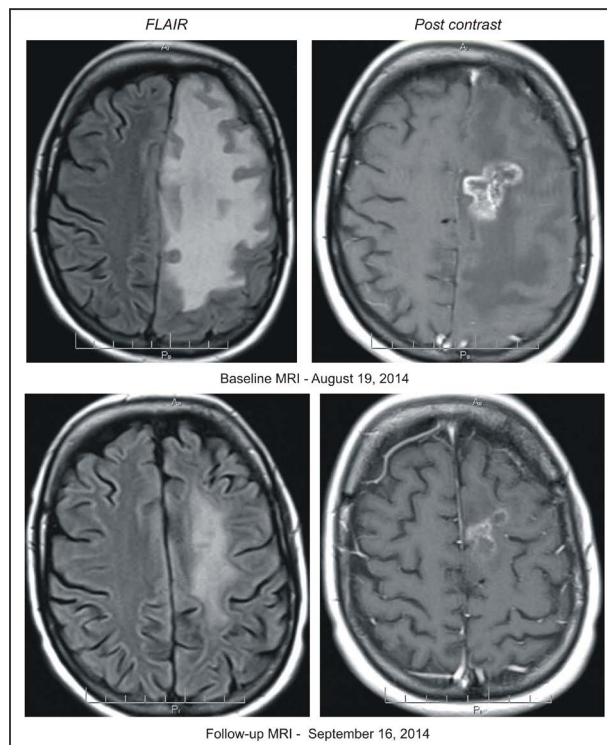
Patient 11, baseline and follow-up MRI of the head indicating partial response.
